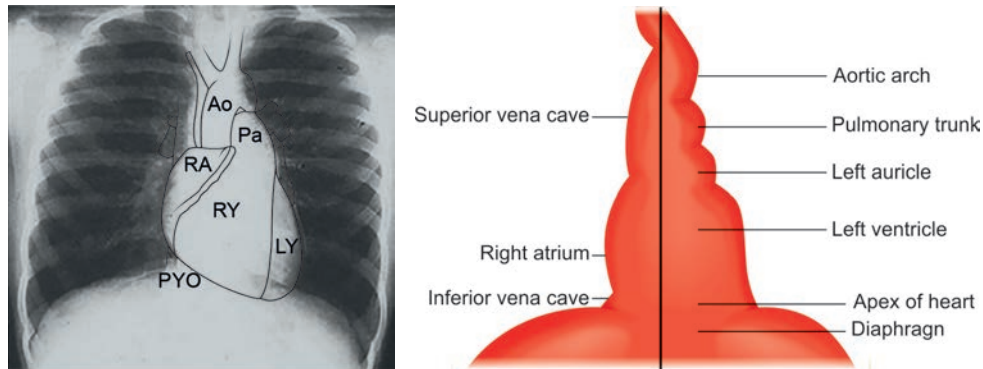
Borders of cardiac silhouette on chest X-ray.
